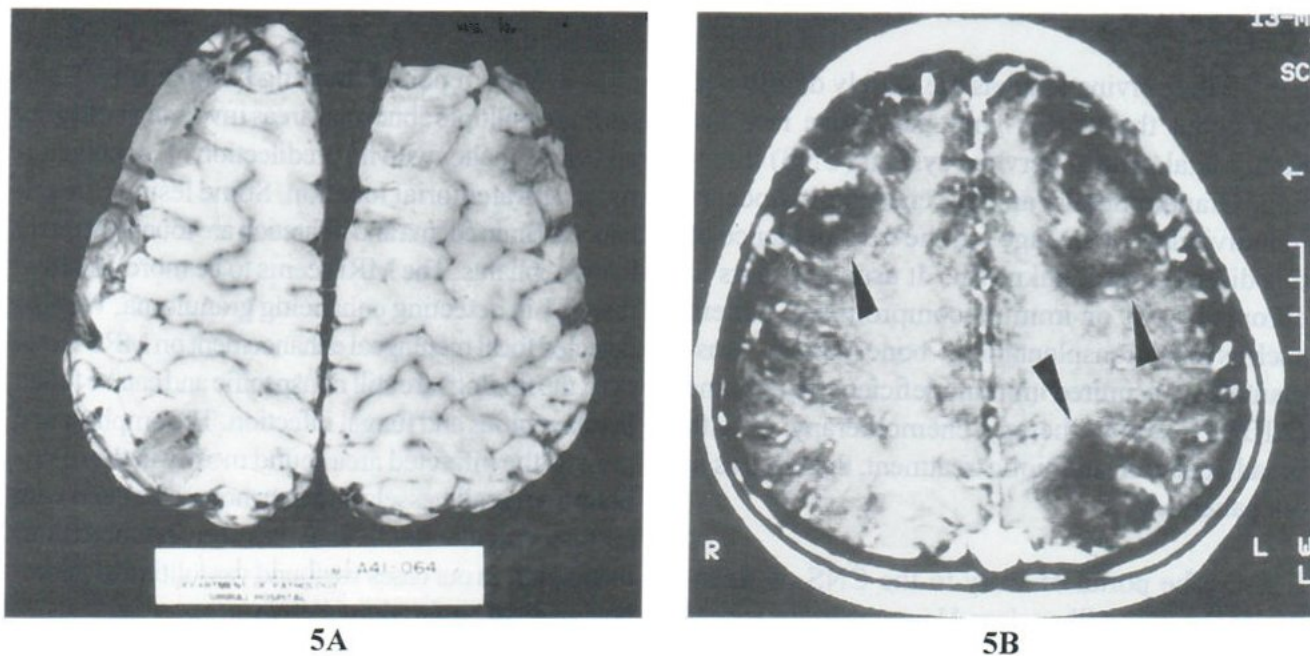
Multiple necrotic nodules focally involved meningeal covering (A). The areas corresponded with infarction on MRI (B).
